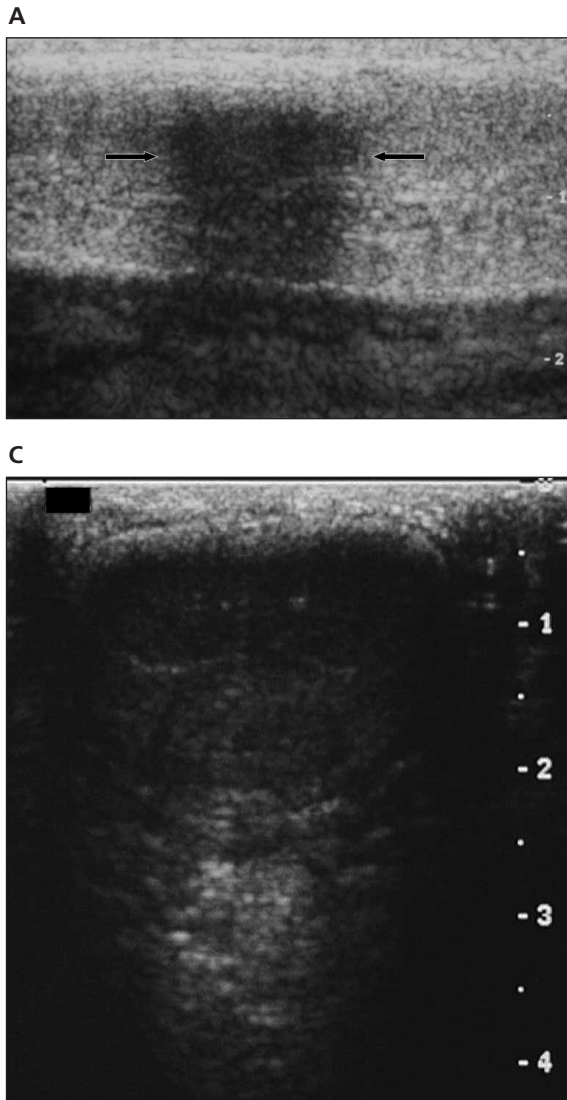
Less common variant of PD showing an isoechoic lesion with curtain attenuation. This aspect has not previously been described in the literature. A, Longitudinal scan, dorsal access. The fibrotic lesion is isoechoic and consequently can not be identified on sonography; only its strong acoustic attenuation can be identified easily (arrows). Good correlation with the symptoms and simultaneous palpation are recommended to find this type of lesion, avoiding false-negative sonographic findings. B, Axial scan, dorsal access. The probe is located over normal penile tissue (no signs or symptoms in this area). The corpora cavernosa and corpus spongiosum can be identified easily because the normal tunica albuginea has good transmission of the acoustic beam. C, Axial scan, dorsal access, exactly over the palpable area of hardening reported by the patient. There is strong bilateral and symmetric attenuation of the sound due to dorsal isoechoic fibrotic bilateral involvement of the tunica albuginea. D, Characteristic attenuation. When the fibrosis affects the dorsal aspect of the penis, including the septum and both dorsal tunica albuginea, symmetrically it causes poor identification of the “posterior” distensible penile tissue (curtain appearance).
